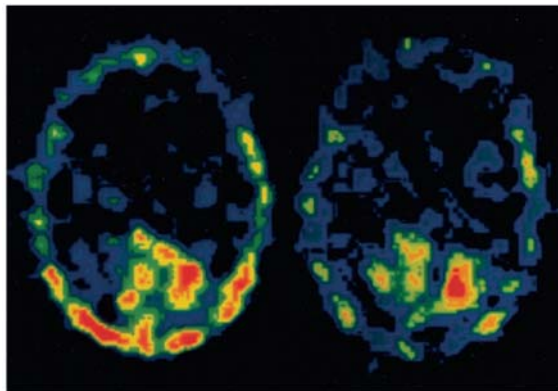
Axial view iodine-123 metaiodobenzylguanidine SPECT scans, obtained 30 minutes (*left*) and 6 hours (*right*) after an IV injection of iodine-123 metaiodobenzylguanidine at a dose of 111 MBq, shows extremely high uptake in the tumour. From Yuichiro et al., 2002¹⁰
